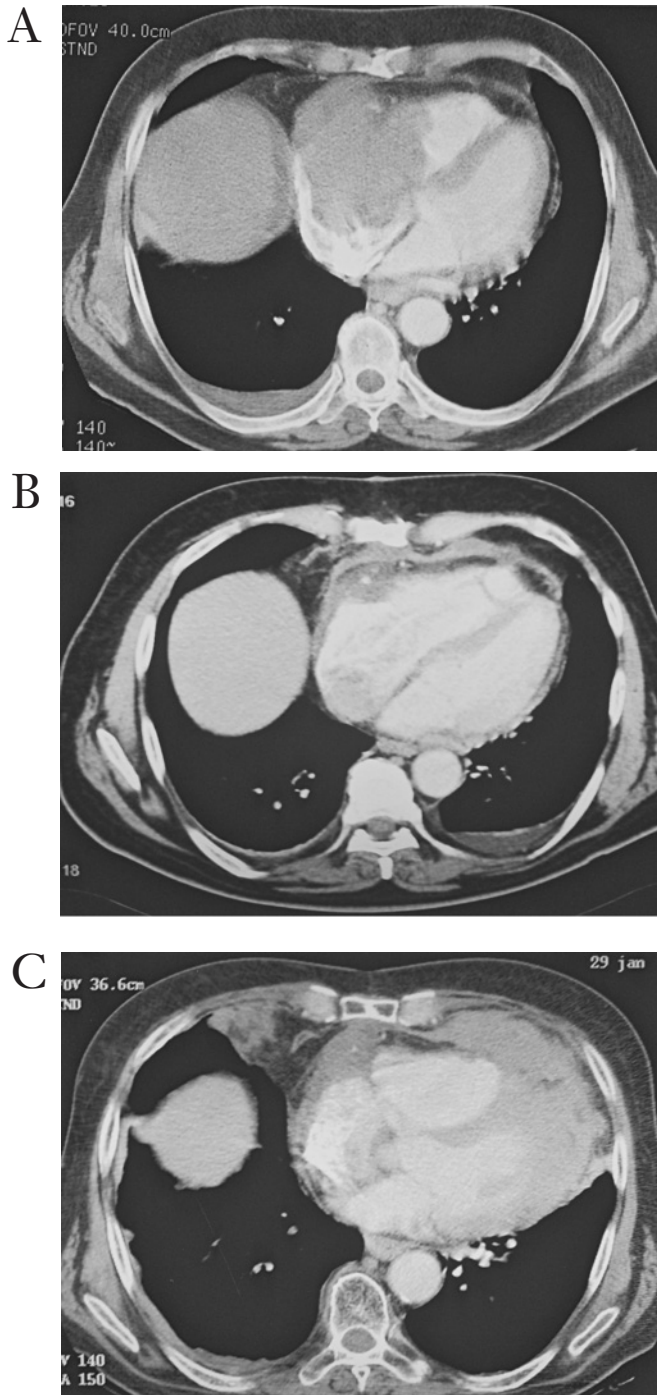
Chest Computed Tomography. A, A voluminous endocavitary mass involves the right cardiac chambers. The pericardium is thickened, especially at its right antero-lateral aspect. B, Aspect of the lumen of the right cardiac chambers after surgical resection of the mass. C, Tumoral invasion of the left ventricle 10 months postoperatively.
